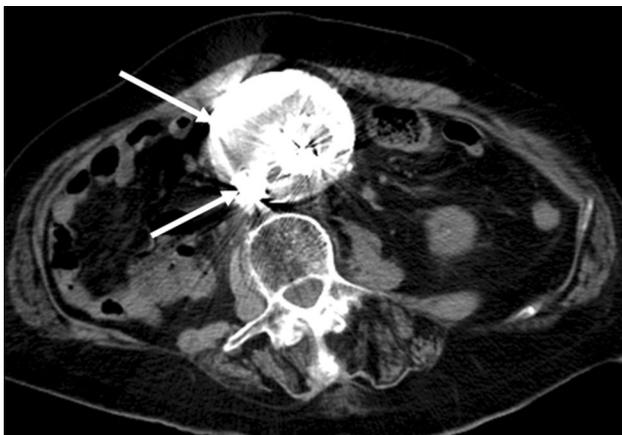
Plain CT 6 months after transgraft sac embolization and graft reinforcement. The sac was stable. Lipiodol accumulation and coils were visualized (white arrows)
